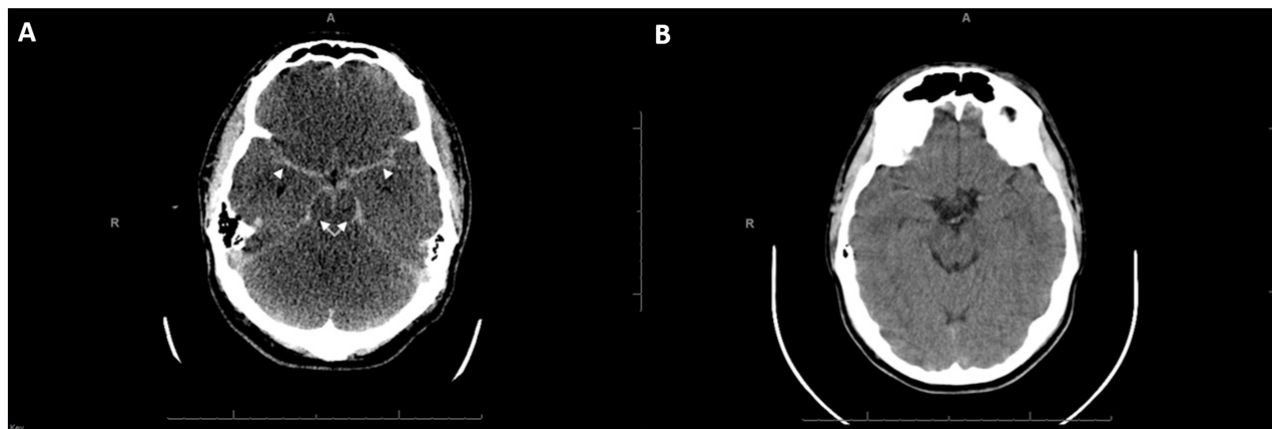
A) Post-resuscitation axial computed tomography (CT) of the brain demonstrating diffusely increased density of the basal cisterns (arrows) and subarachnoid spaces (arrowheads); and B) normal axial CT of the brain obtained on prior visit.
